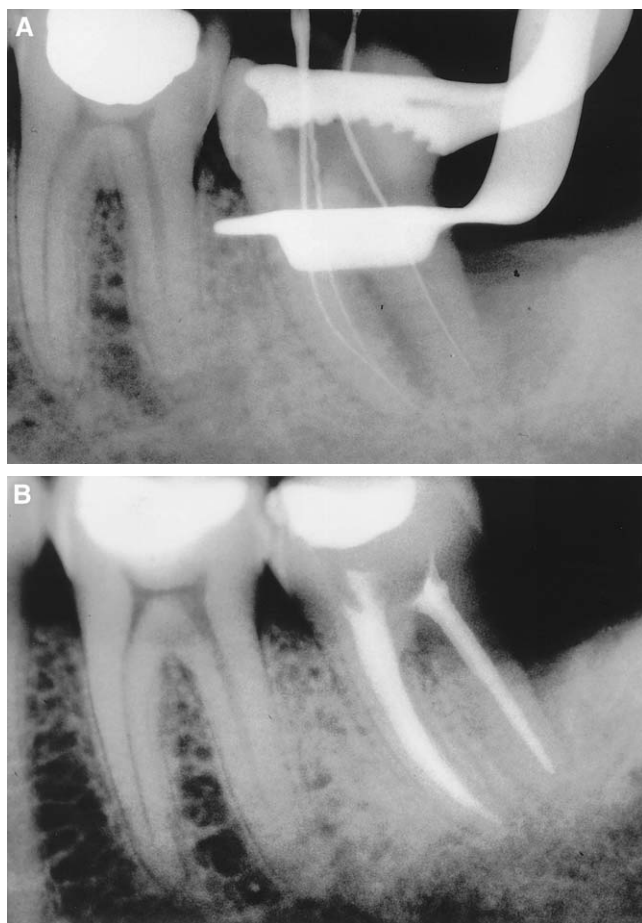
(A) Working length radiograph of a mandibular second molar scheduled for preparation with LightSpeed instruments using the “Zurich technique” (November 1994). Note the endo-perio lesion adjacent to the distal root (case supplied by Dr. J. Zafran). (B) Eighteen-month follow-up radiograph of the mandibular second molar shown in Fig. 8A (April 1996) obturated with ThermaFil. MAR in the two mesial canals and one distal canal were sizes 42.5 and 50, respectively. Note the healed endo-perio lesion adjacent to the distal root (case supplied by Dr. J. Zafran).
